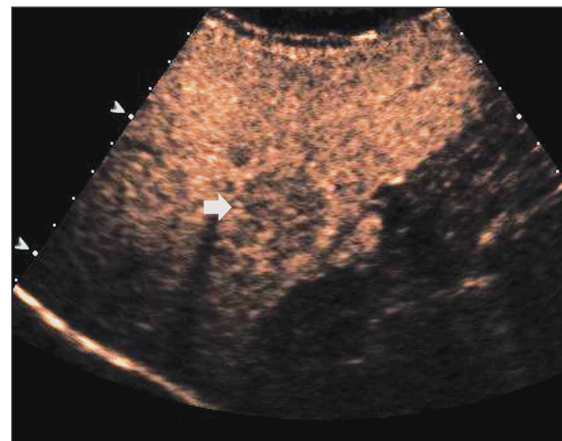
Tumor enhancement degree scored as +1 in a 40-year-old man with focal nodular hyperplasia (arrow) scanned 60 seconds after ultrasound contrast agent injection during the portal phase. The tumor has a hyperenhancing appearance with an echo signal intensity slightly higher (less than double) than that of the adjacent liver.
